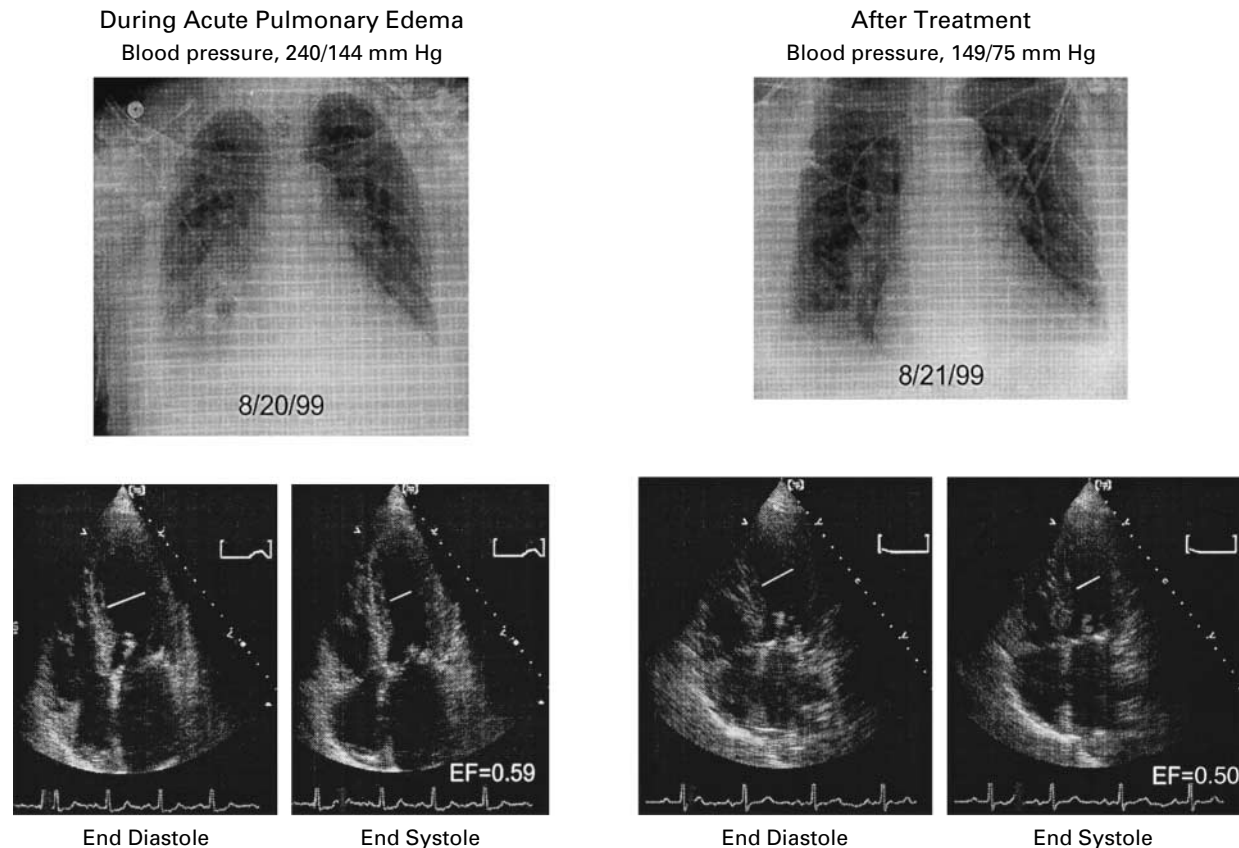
Chest Radiographs and End-Diastolic and End-Systolic Apical Four-Chamber Echocardiograms from a Representative Patient, Obtained on Presentation with Acute Pulmonary Edema and Again after Treatment. EF denotes ejection fraction.
